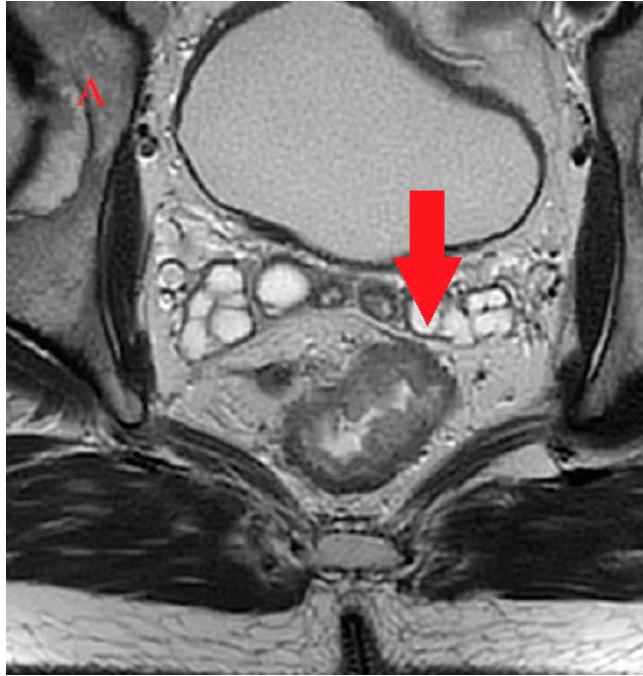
Representative MRI scans showing the involvement of the anterior peritoneal reflection
